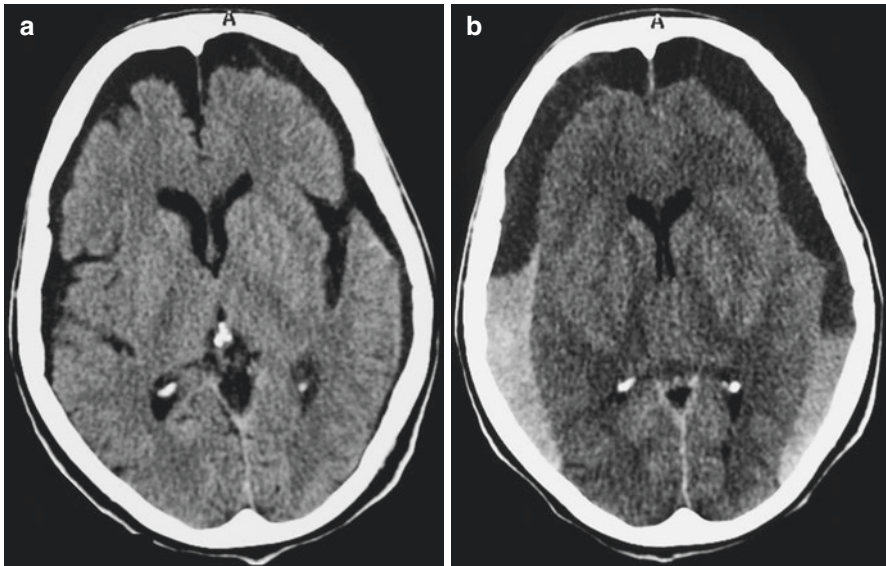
Case 2. This 60-year-old woman with psychiatric illness had a fall. Initial CT-scan on the third day after trauma shows small bifrontal subdural hygromas (a). Here neurological status worsened 2 months later. Bilateral chronic subdural hematomas mixed with acute bleeding were evident on the control CT-scan (b)
